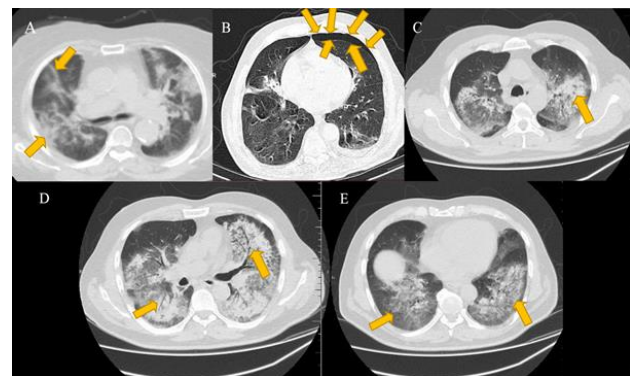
A) Axial HRCT of a 76 years old woman with a lung score of 12 revealed patchy ground-glass opacities in the right upper and right middle lobes (Yellow arrows denote the lesions). Ground glass lesions are also seen in the contralateral lobe. B) Axial HRCT of a 56 years old male with a lung score of 13 shows a pleural edge line due to pneumothorax in the left hemithorax (Yellow arrows delineate the contour of the line). C) HRCT of an 80 years old man, lung score of 18 with bilateral ground-glass opacities and left upper lobe alveolar consolidation. D) HRCT of an 82-year-old man, lung score of 23 with bilateral right and left ground-glass opacities, and alveolar consolidation with air-bronchogram. E) HRCT of a 78 years old man, lung score of 18 with bilateral right and left lower lobe ground-glass opacities.
